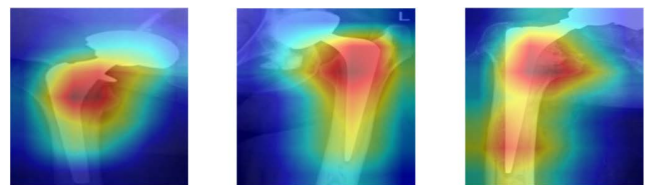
Score-CAM visualization of some loose hip implant X-ray images, to demonstrate the region where the CNN model is mostly making decisions from.
